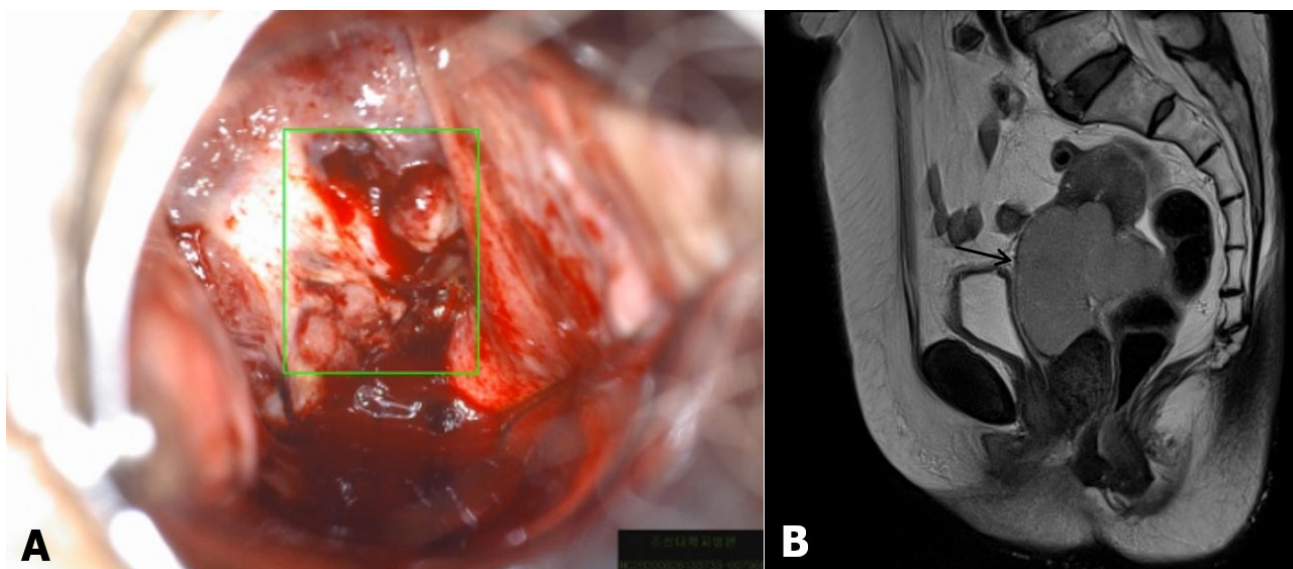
Telecervicography showed whitish hemorrhagic mass lesion with ulcerative surface occupying the uterine cervix (A). Pelvic MRI revealed heterogeneous enhancing mass, suggesting rectal invasion (B, arrow).
